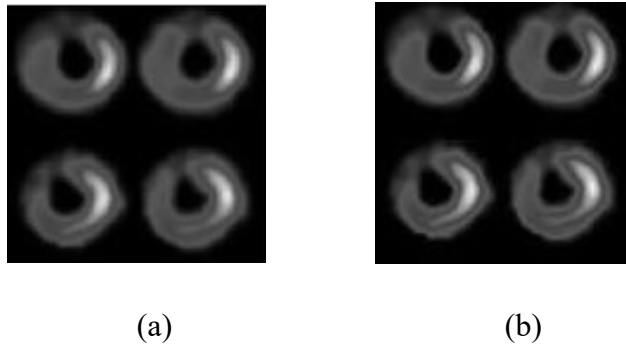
(a) Cardiac SPECT image blurred using a Gaussian PSF with $\sigma=3$ and (b) Deblurred image using the proposed method
